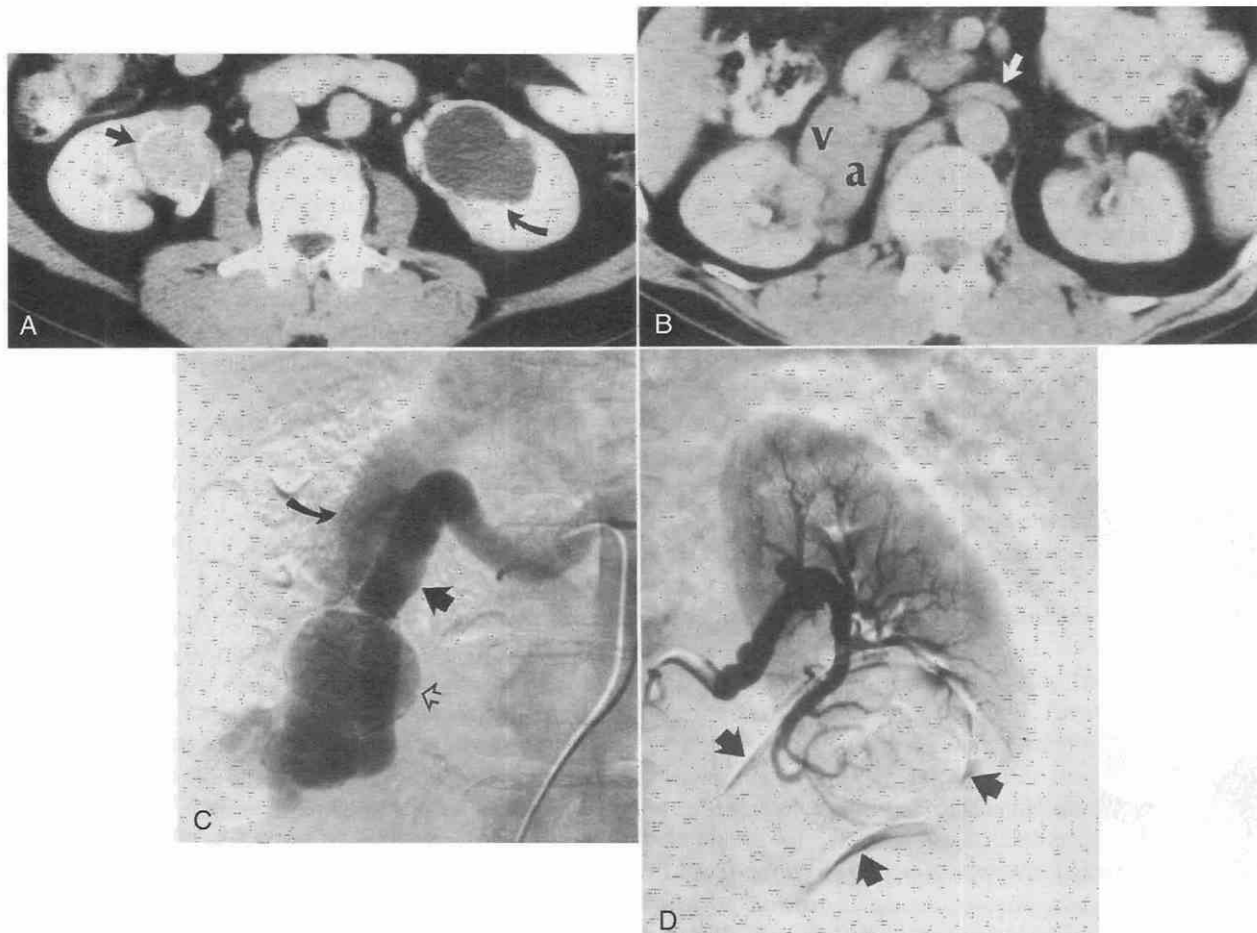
Bilateral renal artery pseudoaneurysms in a patient with a history of previous trauma. *A*, Contrast-enhanced CT scan shows an enhancing mass with peripheral calcification (arrow) in the lower part of the right renal hilus. There is also a nonenhancing mass with peripheral calcification (curved arrow) in the lower part of the left renal hilus. *B*, Cephalad scan reveals significant enlargement of the right renal artery (a) and vein (v), indicating an arteriovenous fistula. The left renal vein (arrow) is normal in size. *C*, Right selective renal arteriogram reveals enlargement of the right renal artery (arrow) and vein (curved arrow). The calcified pseudoaneurysm is opacified (open arrow). *D*, The left renal artery pseudoaneurysm (arrows) does not opacify because of thrombosis.
